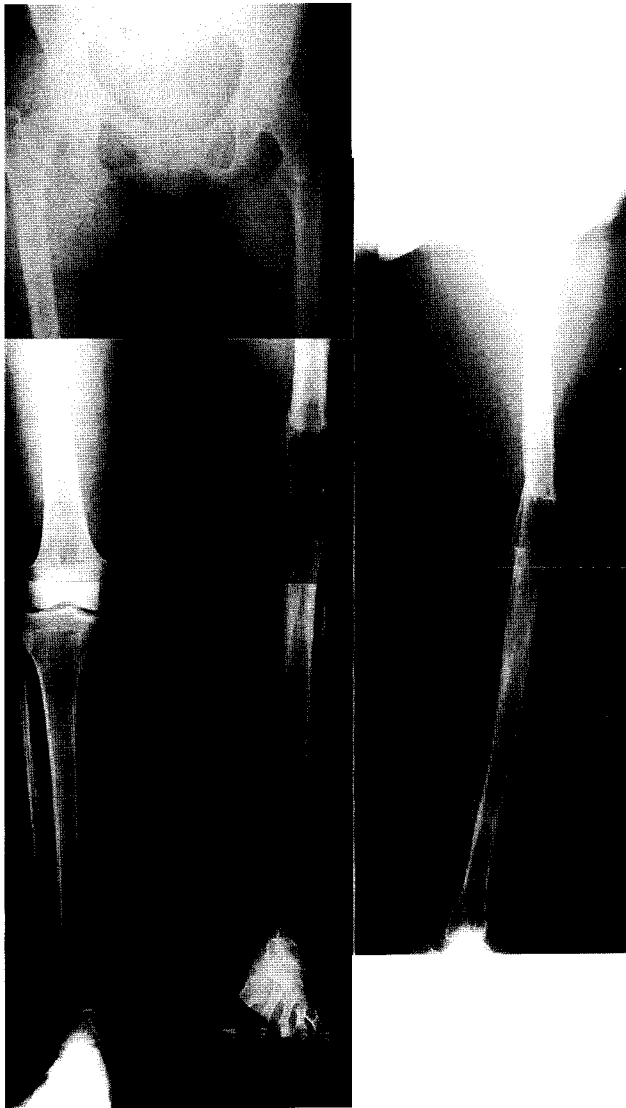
Anteroposterior and lateral radiographs taken two months after removal of the apparatus, showing sufficient union of the docking and elongated sites.
